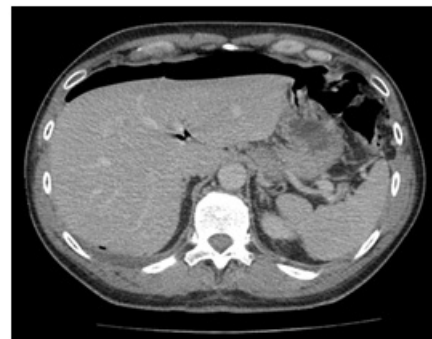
CT scan that shows free air under the right diaphragm without other signs of JID perforation.
